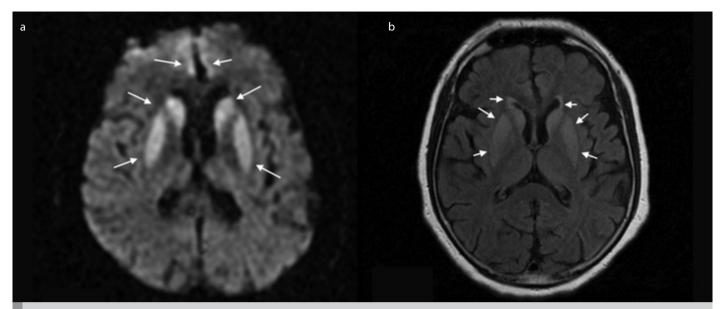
a, b. MRI of the brain with DWI sequences images show increased signal intensity predominantly in the bilateral caudate nucleus, putamen, posteromedial thalamus, and frontal cortex (a), MRI of the brain with FLAIR sequences images show increased signal intensity predominantly in the bilateral caudate nucleus, putamen, posteromedial thalamus, and frontal cortex (b)
